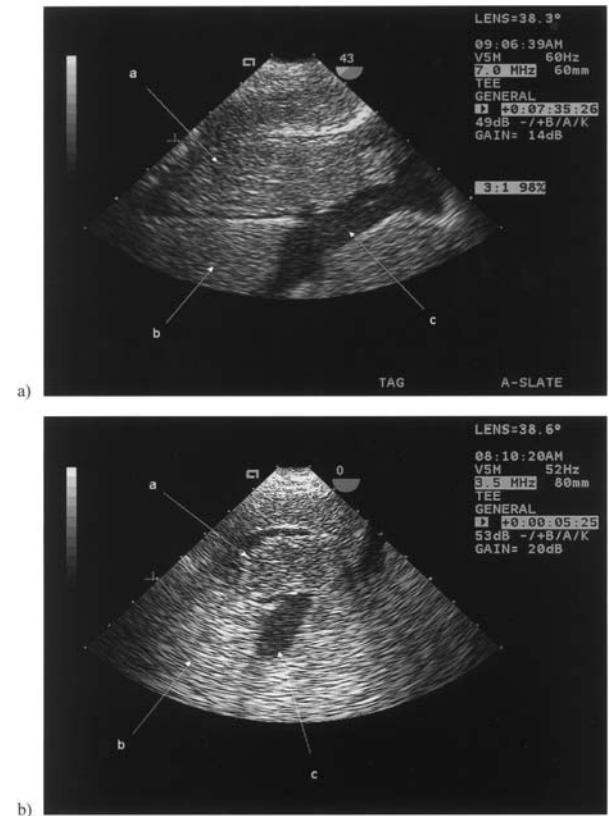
Longitudinal transesophageal echocardiography (TEE) view revealing tumour thrombus (a) in the inferior vena cava (IVC) extending up through the liver (b). The tumour extends proximally beyond where the portal vein (c) enters the IVC.
